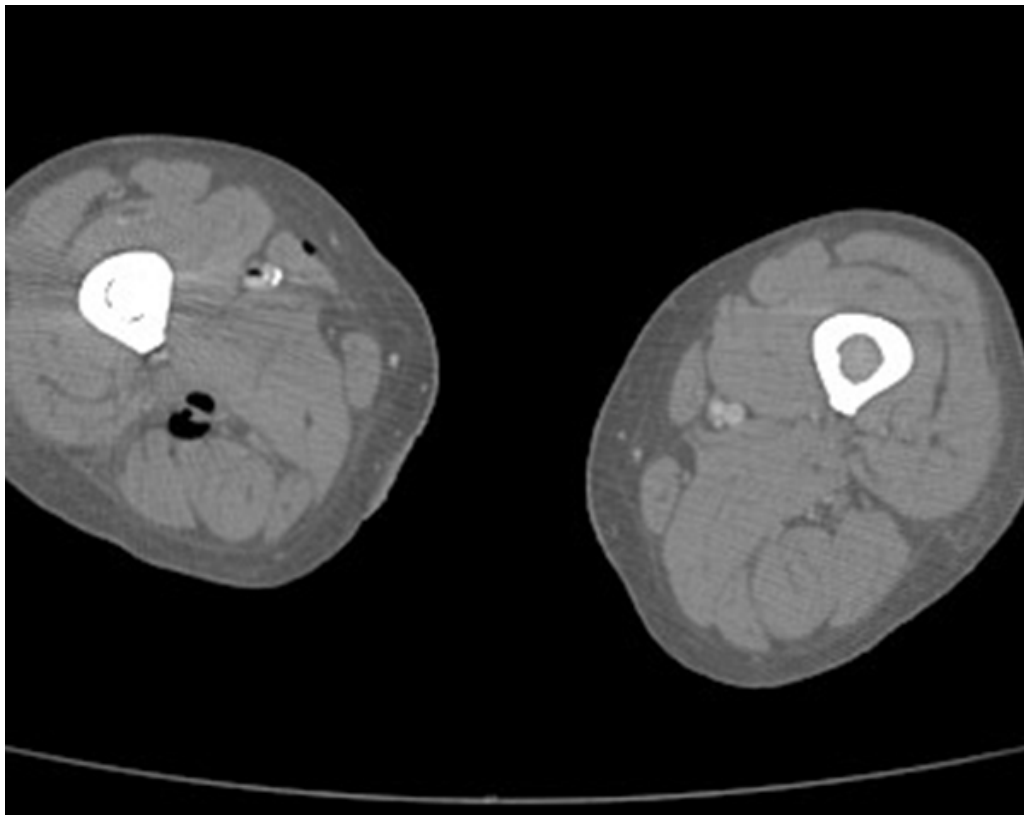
Cross-sectional image of computed tomography scan showing compression of arteries of the right lower limb by gas
